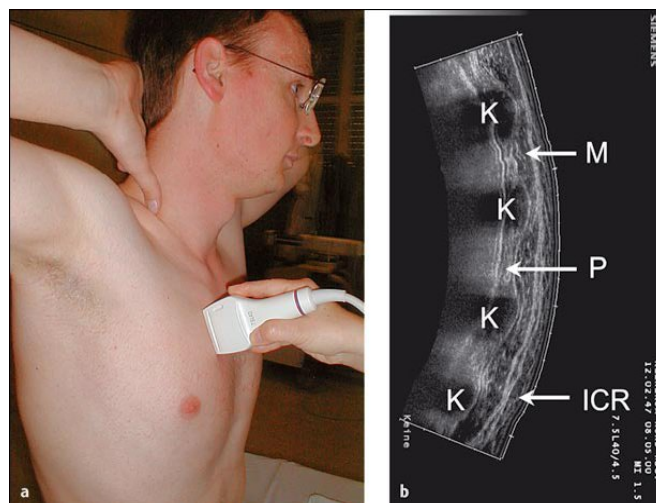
Examination of the seated patient (a) Linear probe placed longitudinally on the right parasternal line. (b) Corresponding sonographic longitudinal panoramic image. K cartilage at the point of insertion of the rib, ICR intercostal space, M muscle, P line of the pleura (*Mathis et al., 2007*).
